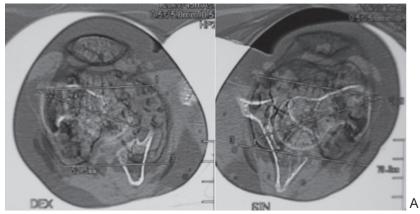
Nonunions of the proximal femur: A-AP X-ray of the pelvis, B-computed tomography
